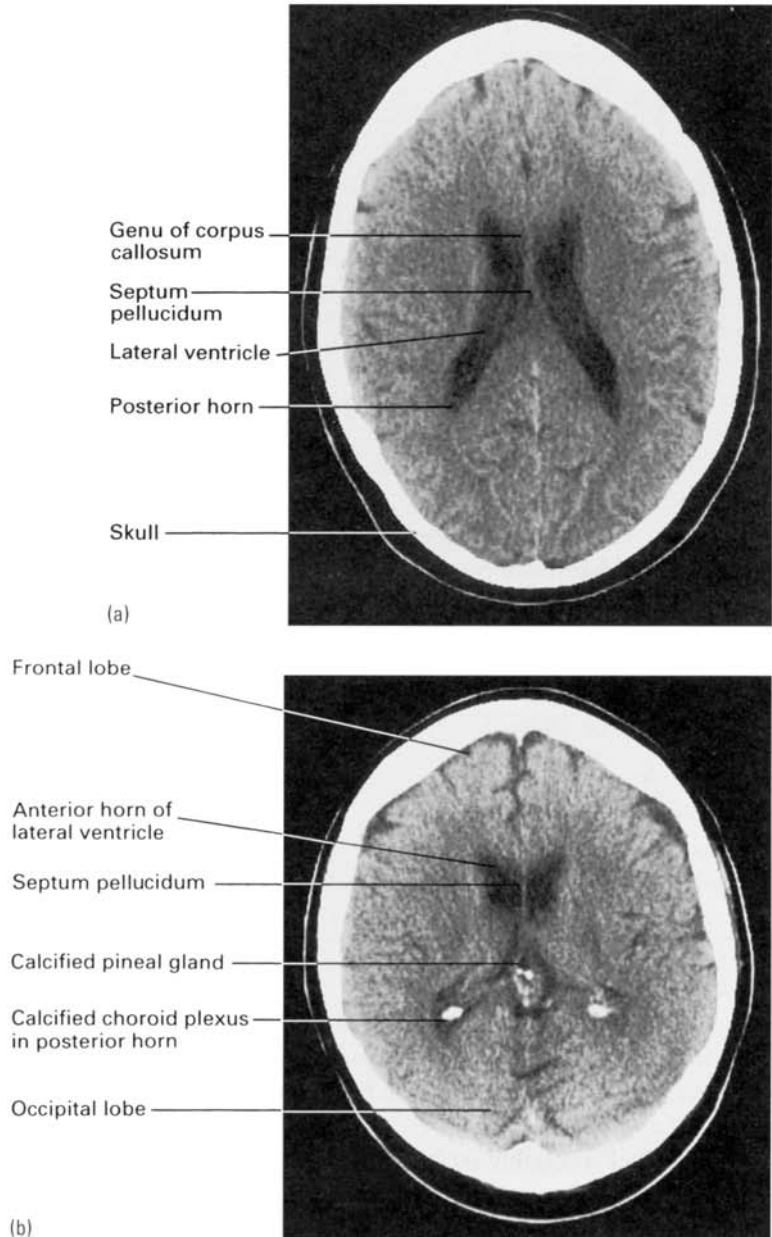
(a) CT scan of skull through the level of the bodies of the lateral ventricles. (b) CT scan cut through the level of the anterior horns of the lateral ventricles.
